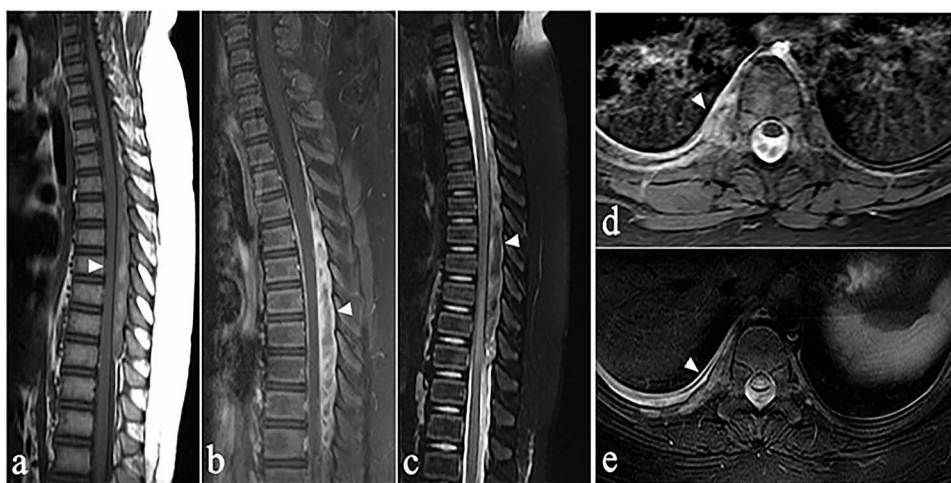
MRI imaging of intraspinal paragonimiasis in a 6-year-old patient (patient 7). As indicated by the white arrowheads, sagittal T1WI (a), contrast-enhanced T1WI (b), and T2WI (c) show that the lesion mainly with isointense on T1WI and hyperintensity on T2WI extends from T2 to T10 and is circumferential, mainly with posterior involvement. Multiple irregular hemorrhagic areas within the lesion, with slight hyperintensity, are shown on T1WI. Contrast-enhanced T1WI shows that lesions and adjacent spinal meninges are enhanced. The spinal cord adjacent to the lesion at the T3-T10 vertebral level is compressed. As indicated by the white arrowheads, axial contrast-enhanced T1WI (d) and T2WI (e) show that the intraspinal lesion is connected to the right pleural lesion through the right intervertebral foramen.
